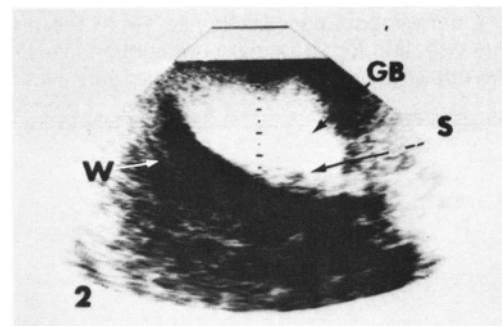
Real-time ultrasound image demonstrates markedly enlarged gallbladder (GB) with thickened walls (W) and sludge formation (S). In this supine patient the anterior aspect of gallbladder is at top of image.
